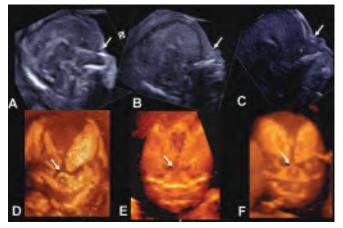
Tomographic ultrasound image of fetal profile with hypoplastic nasal bone at the end of 13 weeks of gestation. Thinly sliced parallel cutting section of midsagittal plane shows fetal profile in detail and hypoplastic nasal bone. Trisomy 21 was confirmed by CVS
